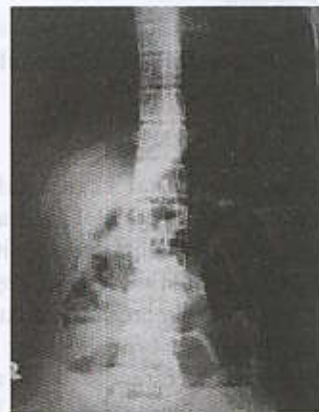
Abdominal plain film, AP-upright.
